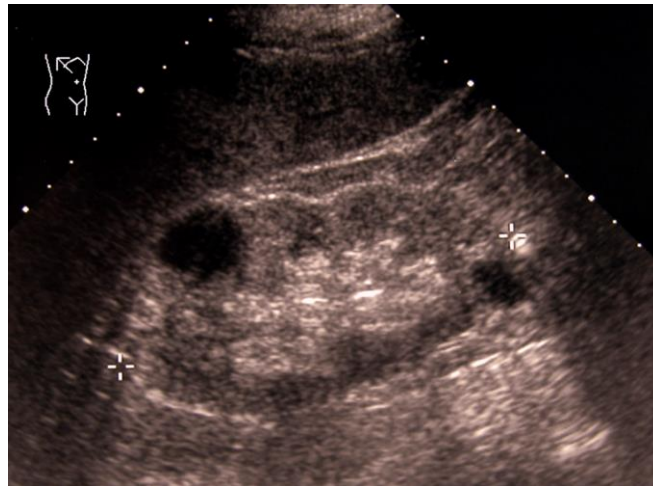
Calyx diverticulum: contrast-enhanced ultrasound helps to differentiate from a cyst. The diverticulum has a clear connection to the collecting system.
